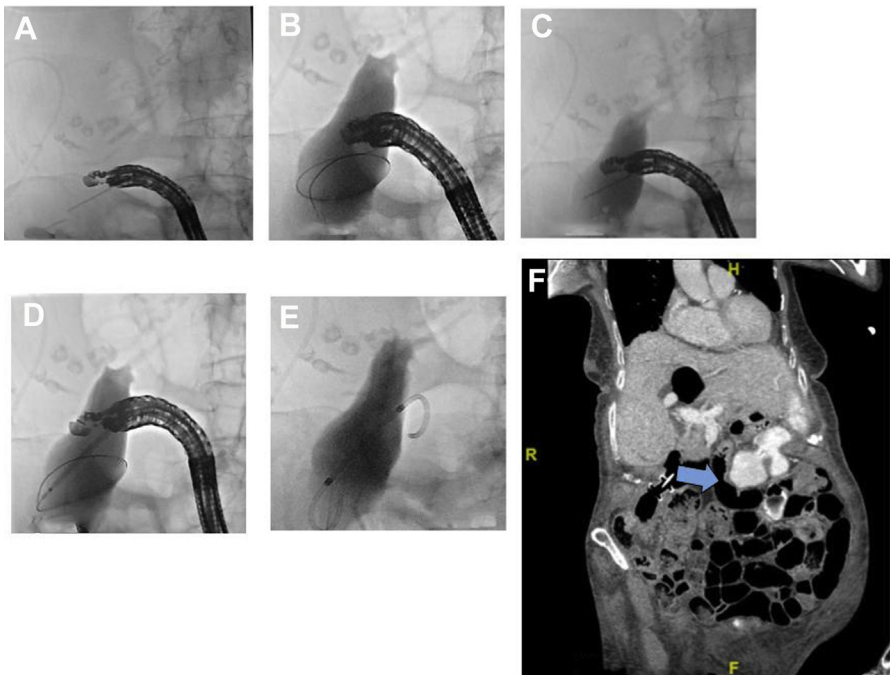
(A–E) Steps of EUS-guided LAMS placement in a patient with acute cholecystitis. (F) CT image of a patient after LAMS placement. Arrow denotes GB Drainage through LAMS.
